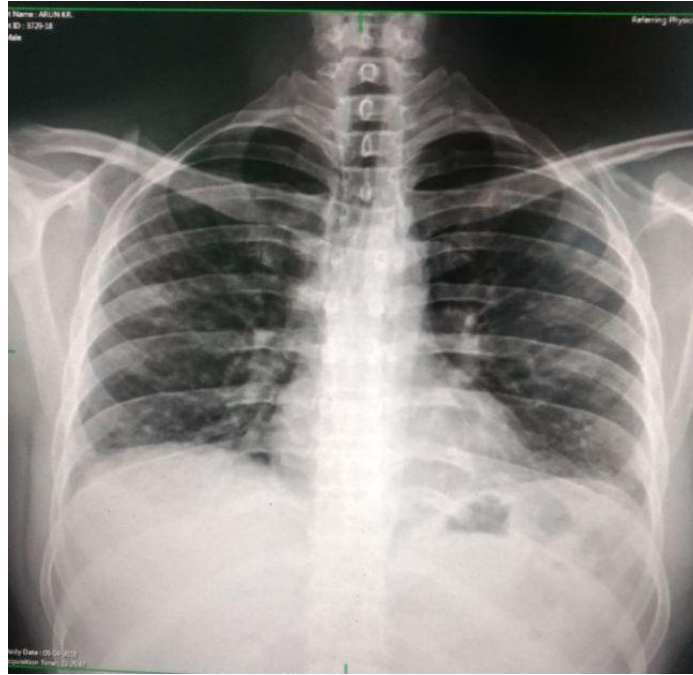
Chest radiograph shows bilateral reticular infiltrates, especially in the lung bases.
